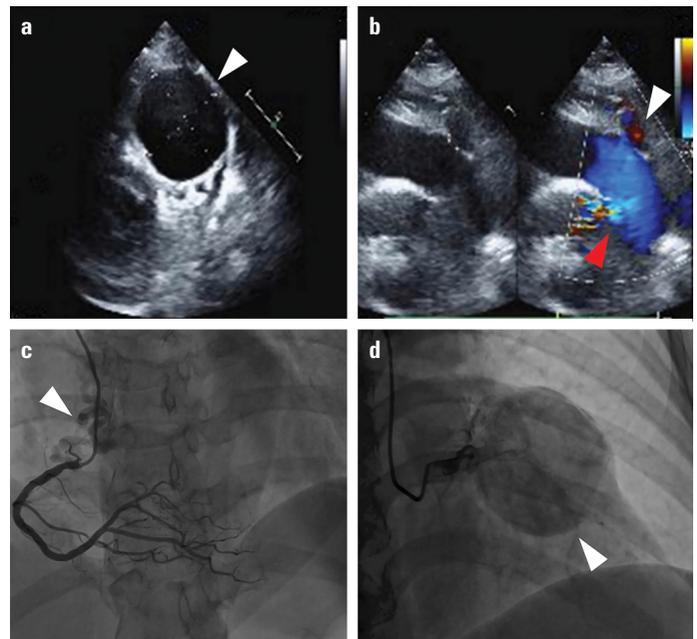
Transthoracic color Doppler echocardiography shows widening of the left coronary artery and a tumor-like dilation outside the pulmonary artery measuring approximately 51×43 mm (white arrow) (a) and (b). The distal end is connected with the inside of the pulmonary artery. The fistula was approximately 10 mm in diameter and approximately 14 mm from the pulmonary valve annulus. The red arrow indicates a fistula and the white one indicates the left coronary artery (b). Coronary angiography: White arrows show right coronary artery fistula (c) and anterior descending giant coronary artery (d)
